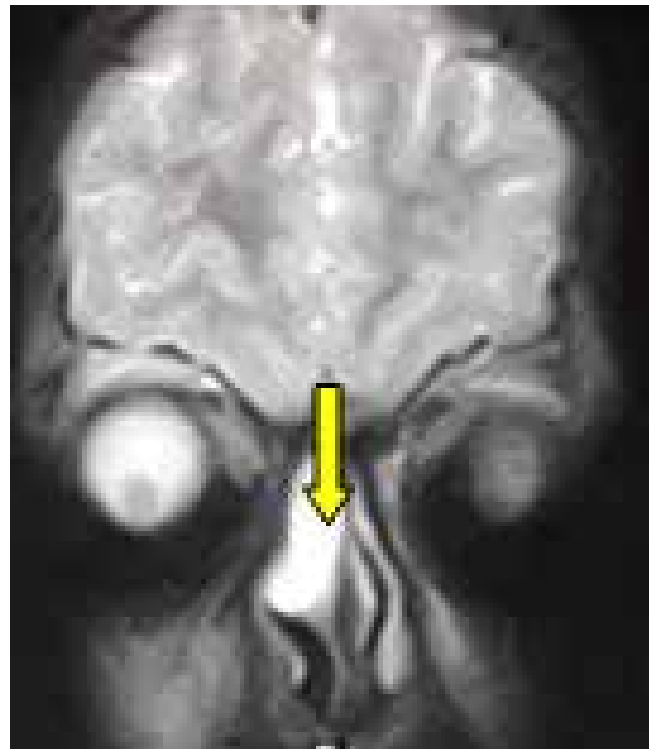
MRI Brain T2 image showing hyperintense lesion in nasal cavity
